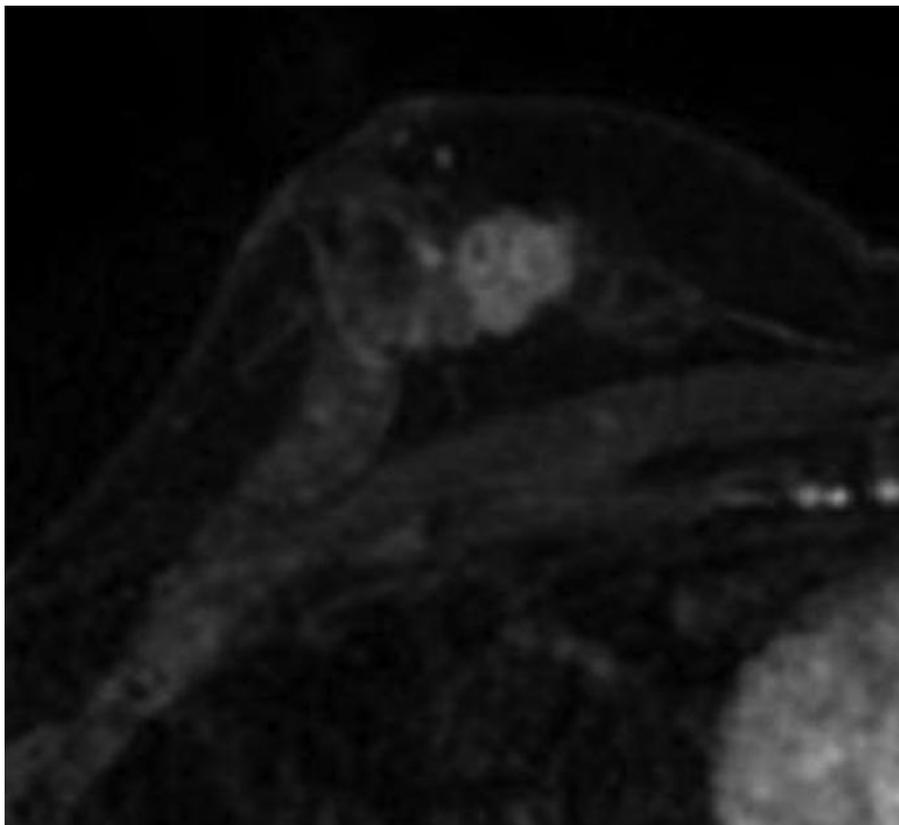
Intraductal papilloma on MRI. Axial MRI T1 vibrant fat-saturated postgadolinium image at 1 min postinjection shows an enhancing lobulated mass in the right breast. The mass had rapid initial enhancement and delayed plateau kinetics. Another papilloma with similar imaging features was observed in the left breast (not shown).
